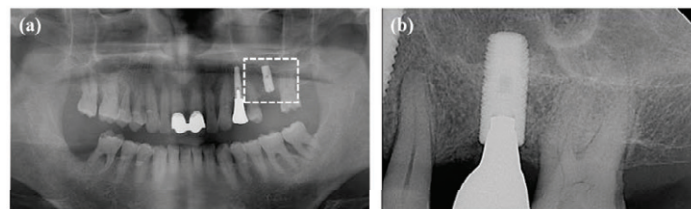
Radiography of sample 3; (a) a panoramic view, (b) a standard view.
